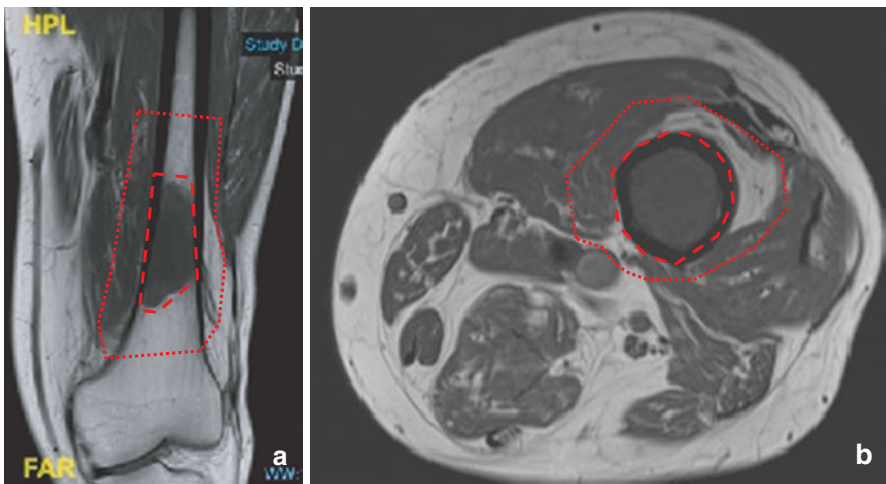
(a) Coronal and (b) axial T1-weighted MRI of femoral bone sarcoma. Intralesional margin passes through tumour, for example, if treated with intramedullary rod fixation or curettage. Marginal margin passes immediately adjacent to tumour and subperiosteally (dashed red line). Wide margin passes includes periosteum and a cuff of surrounding muscle or fascia (dotted red line). The proximal and distal bone margin is at least 2 cm but may be as wide as 5 cm from the tumour depending on the response to chemotherapy
